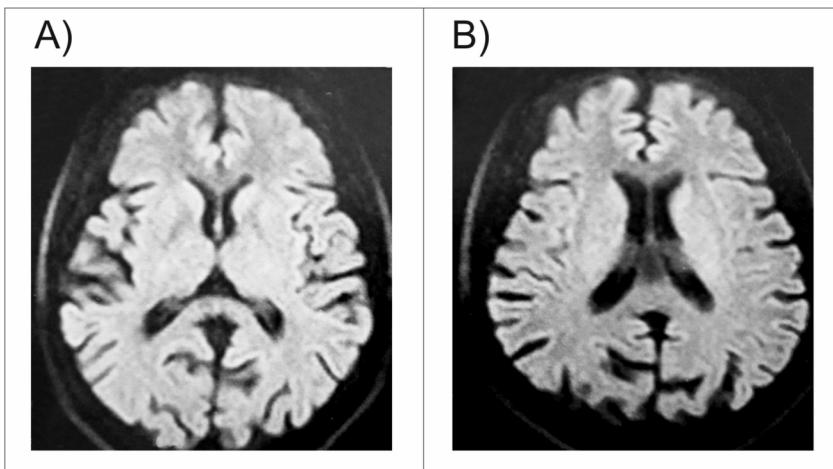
Axial brain MRI showing parietal atrophy
